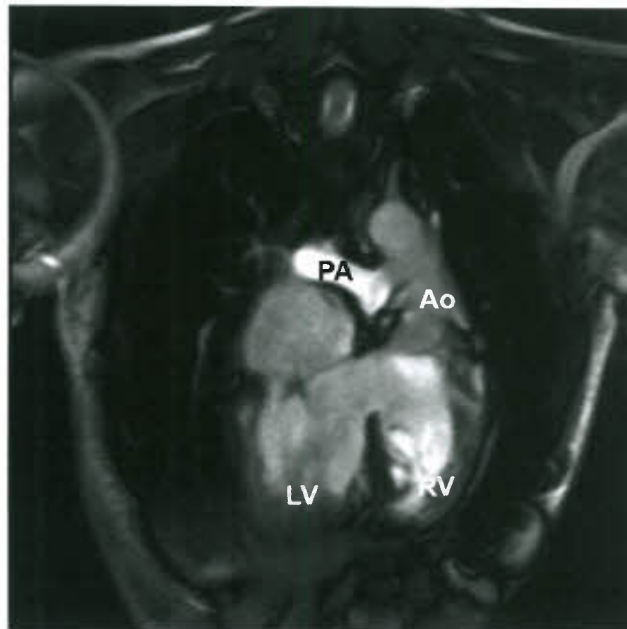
Frontal cut of T2-weighted MRI, in congenitally corrected transposition of the great arteries with mesocardia, ventricular septal defect, and pulmonary atresia. (Ao, aorta; LV, left ventricle; PA, pulmonary artery; RV, right ventricle.)
